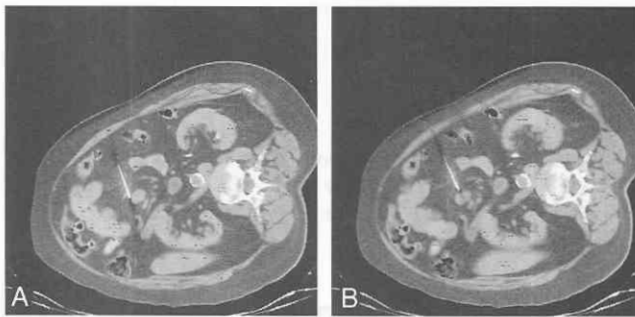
A, Small lesions in deep locations can only be sampled using CT. Scan shows a tiny mass in the root of the mesentery. This first pass shows the needle (arrow) deflecting past the mass. Note that the patient was positioned obliquely, which permitted the bowel to float away slightly, thereby clearing a pathway for the needle. B, Repositioning of the needle and using the bevel of the needle to prevent deflection, the mass was sampled adequately. See section on needle deflection.
